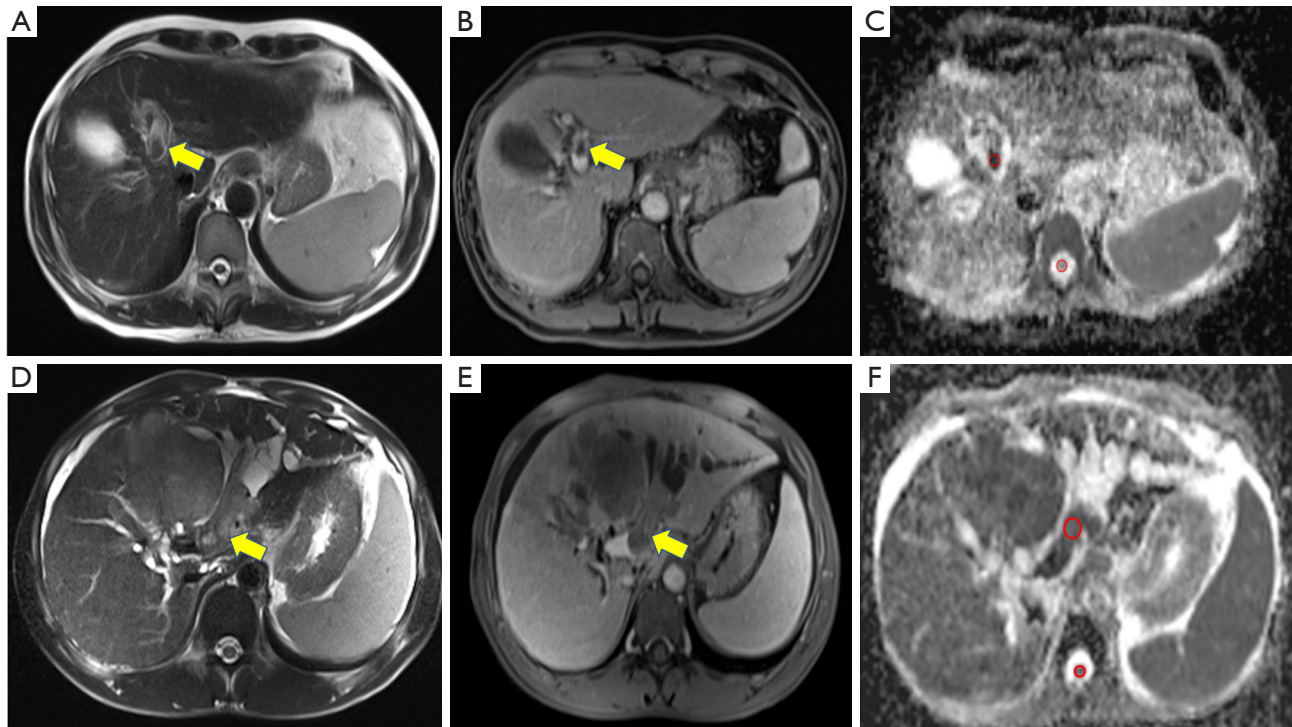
(A-C) Benign PVT in a 59-year-old man. PVT (yellow arrow) appears hypointense on T₂WI (A). PVT is also shown on the portal venous phase (yellow arrow) on enhanced MRI (B). The sample image of the ROI placement over the PVT and spinal cord (red circles) on the ADC map (C). (D-F) Malignant PVT in a 40-year-old man with cirrhosis and HCC. PVT (yellow arrow) appears mildly hyperintense on T₂WI (D). PVT is also shown on the portal venous phase (yellow arrow) on enhanced MRI (E). The sample image of the ROI placement over the PVT and spinal cord (red circles) on the ADC map (F). PVT, portal vein thrombosis; T₂WI, T₂-weighted imaging; MRI, magnetic resonance imaging; ROI, region of interest; ADC, apparent diffusion coefficient; HCC, hepatocellular carcinoma.
